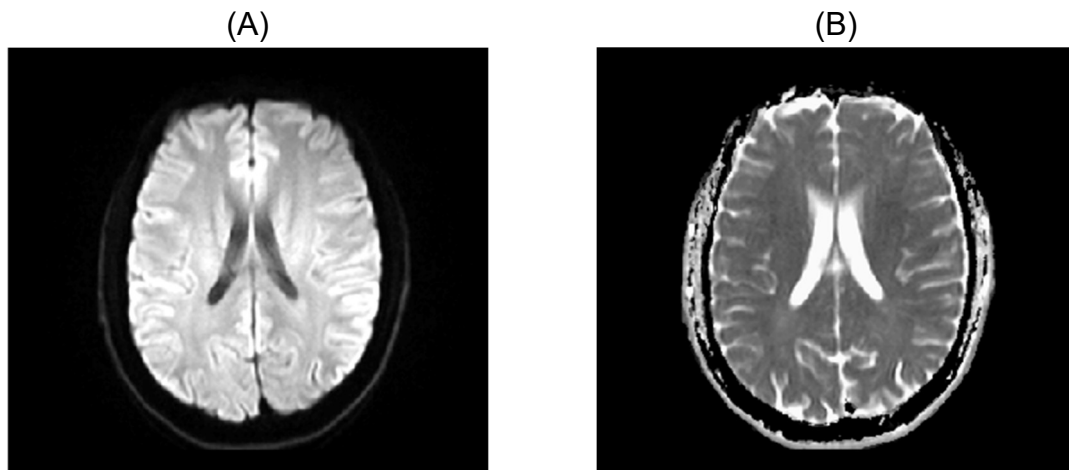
Diffusion-weighted imaging (DWI)-derived maps. Healthy volunteer, male 23 years old. (A) DWI trace, which correspond to the average of the x -, y -, and z - directions and represents the average degree of signal lost due to water diffusion. This results in an image with a contrast that does not depend on the diffusion directions (isotropic). (B) Apparent diffusion coefficient map, calculated using the trace image.
